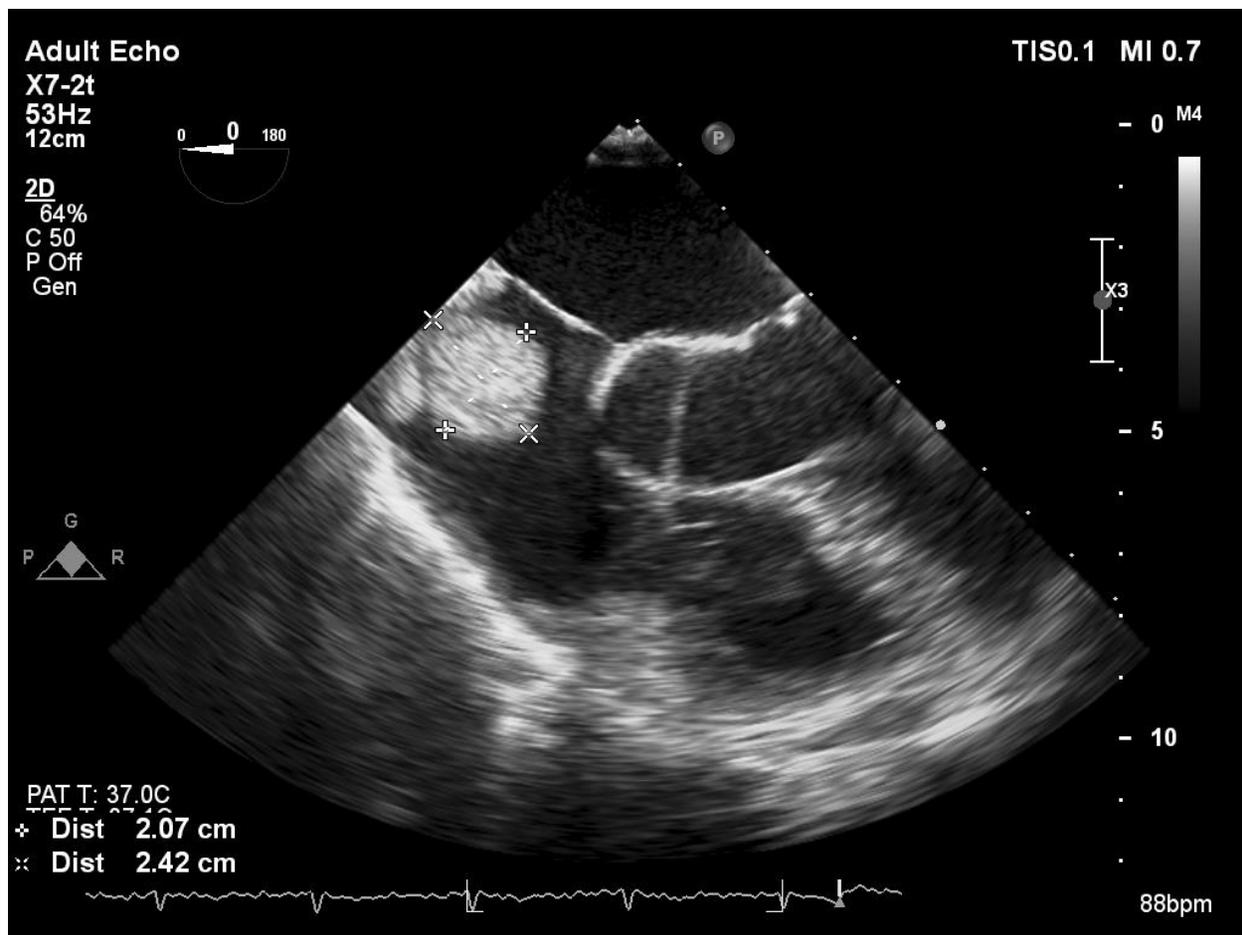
The 4-chamber view of the right atrium in transesophageal echocardiography shows that the mass originates from the superior vena cava.
